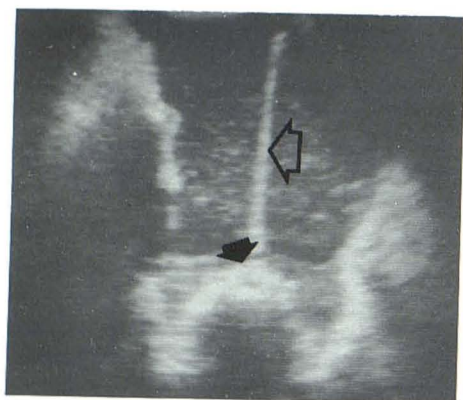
Case 1. Transverse intraoperative sonogram of L4–L5 laminectomy site. Microbubbles in saline bathe dural sac. Metal cannula (*open arrow*) demarcates dural interface (*solid arrow*), which is thickened and impedes acoustic signal to further through-transmission.
